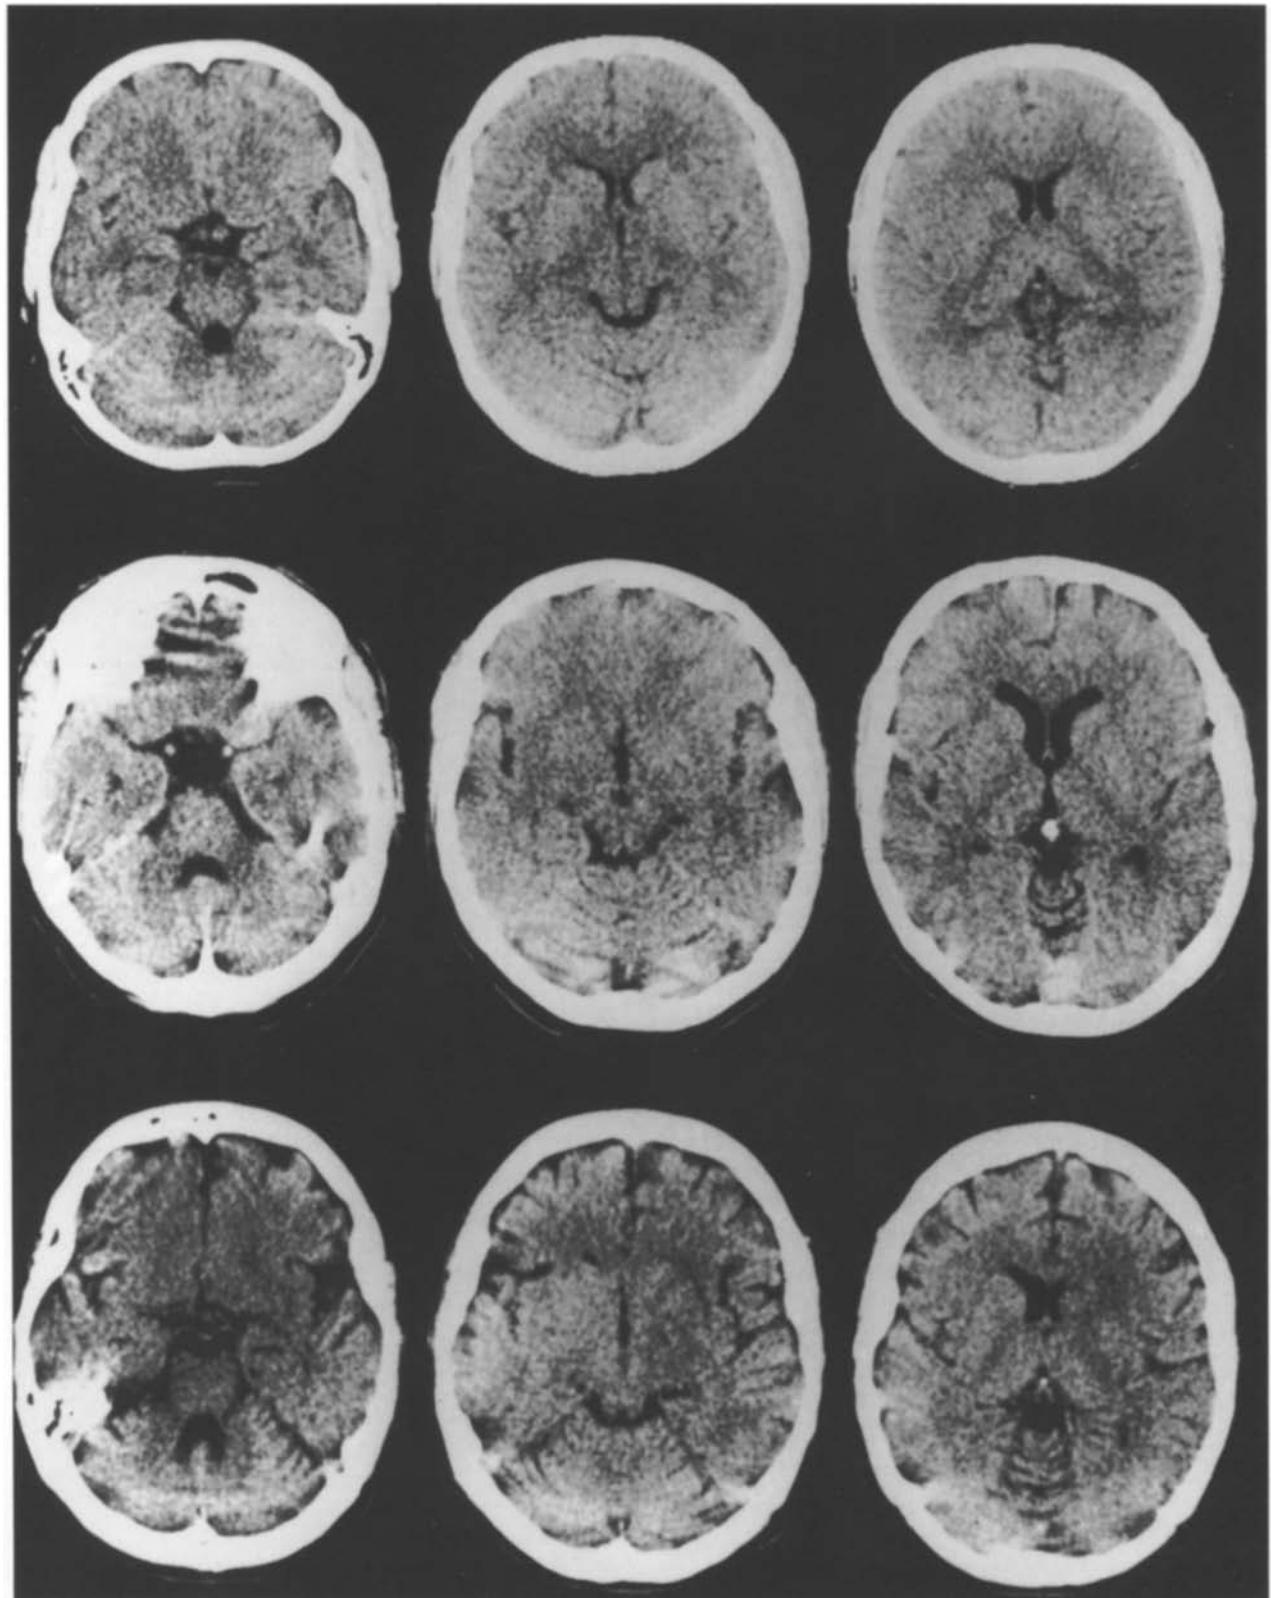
CT scans of three patients with Friedreich's ataxia. Normal CT scans (*upper panels*); mild (grade 1) cerebellar atrophy (*middle*); cerebellar atrophy (grade 3) together with global cerebral atrophy (*lower panels*)
